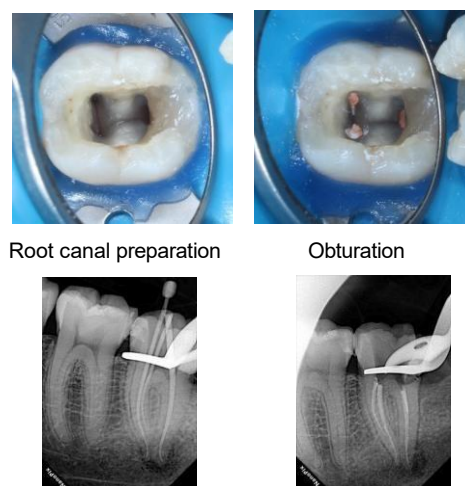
a) Root canal preparation using a combination of Protapper Ultimate and Trunatomy. b) MAC evaluation using periapical X-rays c) Root canal obturation d) Evaluation of root canal obstruction results using periapical X-ray.
